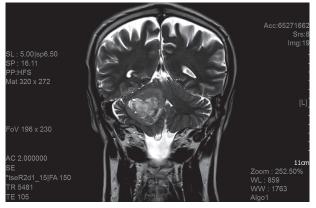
MRI of head before treatment - coronal
